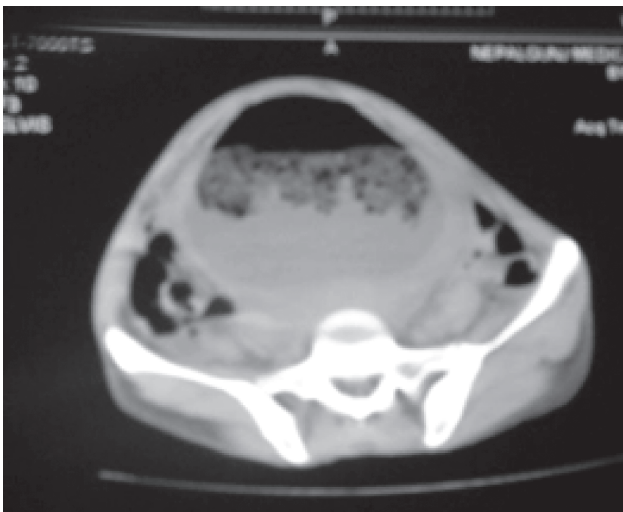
CT scan Pelvis Showing a large well defined cystic lesion with air, fat and fluid level. Bowel loops are displaced laterally
